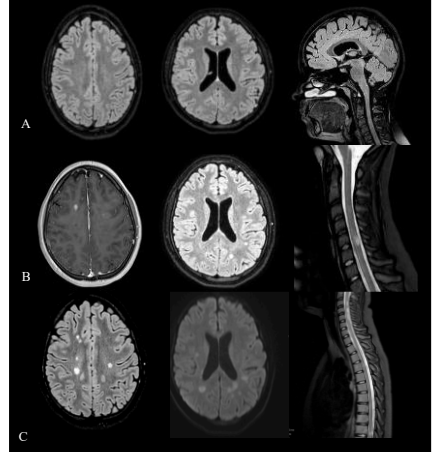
Initial MRI showed no abnormalities (A). Three months later, brain and spinal cord MRI with gadolinium-based contrast revealed multiple enhancing lesions (B). After 210 days (relapse), coinciding with the onset of new clinical symptoms, a gadolinium-enhanced MRI demonstrated marked disease activity (C).
